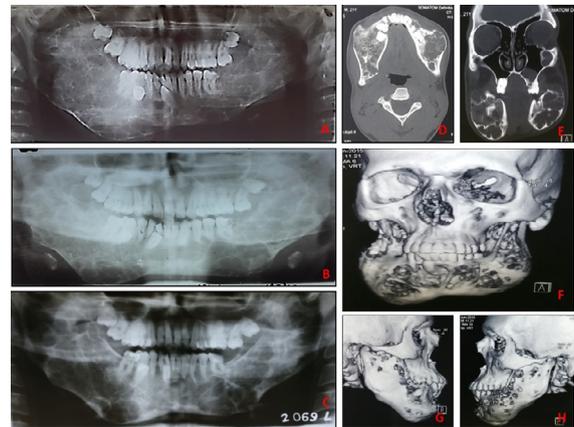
Case 2. (A) Panoramic radiograph showing bilateral multilocular, osteolytic lesions involving the mandible with a thinned and expanded cortex, no involvement of the condyle bilaterally, developing teeth 1, 16, and impacted 27, 29 at 13 years. (B) Panoramic radiograph showing bilateral osteolytic lesions involving the mandible with expanded cortex at 15 years. (C) Panoramic radiograph showing significant regression and remodeling of involved bone with patchy areas of ground-glass appearance at 23 years. (D), (E) Axial and coronal computed tomography (CT) section showing significant remodeling of mandibular bone with patchy areas of ground-glass appearance, also seen in the lateral wall of the left maxillary antrum at 21 years. (F), (G), (H) Three-dimensional (3D) CT reconstruction (frontal and lateral) showing a small osteolytic multilocular lesion along with remodeling of new bone in the mandible but no evidence of condylar involvement bilaterally at 21 years.
